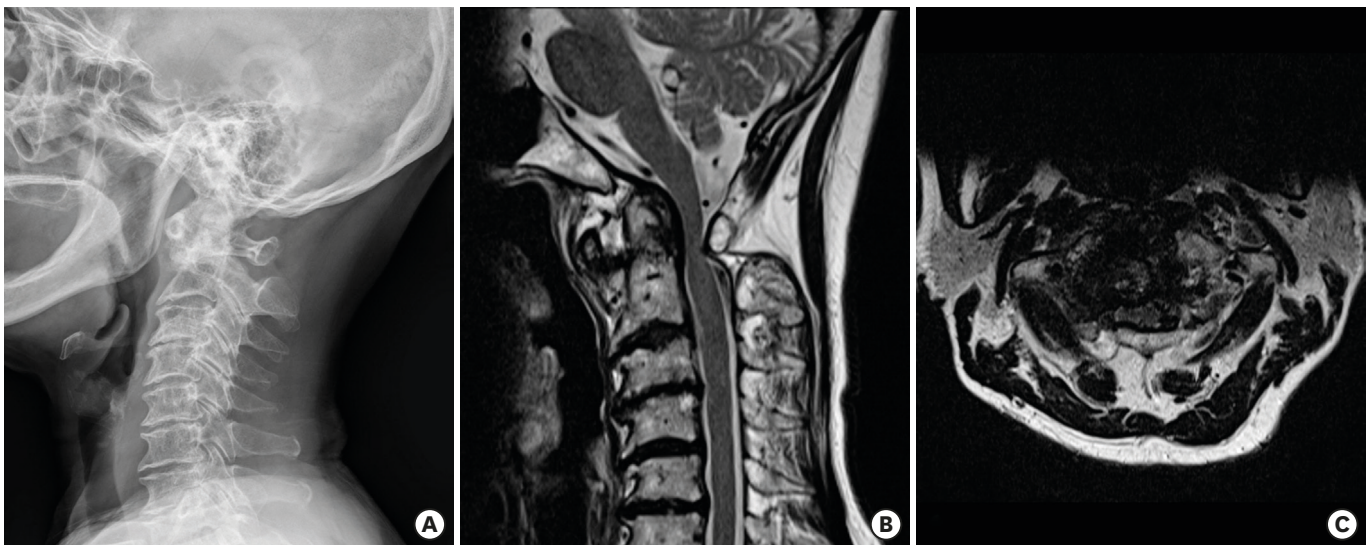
Preoperative images. (A) C-spine plain radiography, lateral view (ADI = 5 mm, PADI = 10.4 mm). (B, C) C-spine magnetic resonance image T2 sagittal and T2 axial view showing cord compression with right foraminal stenosis on C1-2. ADI: atlanto-dens interval, PADI: posterior atlanto-dens-interval.
